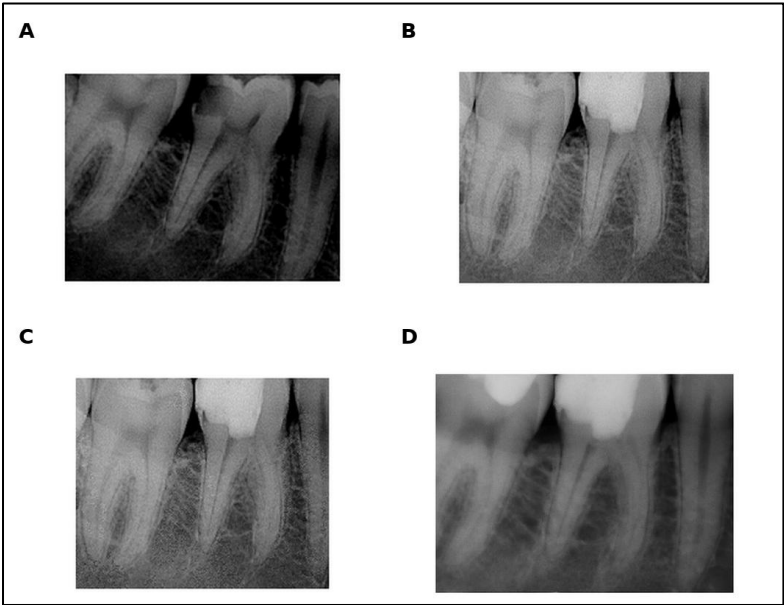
Case 1 radiographic sequence for tooth 46. A: preoperative radiograph; B: immediate postoperative radiograph; C: 6-month follow-up; D: 12-month follow-up.
